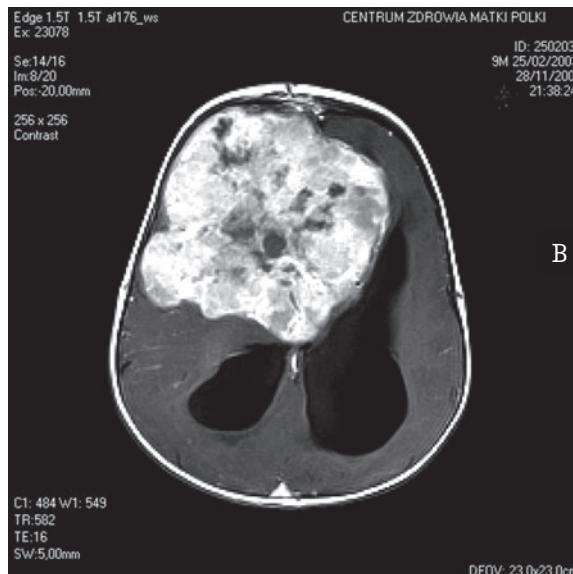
Axial T1-weighted noncontrast (A) and after contrast administration (B) images show huge, heterogeneous tumor (astrocytoma) in the anterior fossa. The peripheral portion of the tumor localized in the frontal horns of the lateral ventricles.
